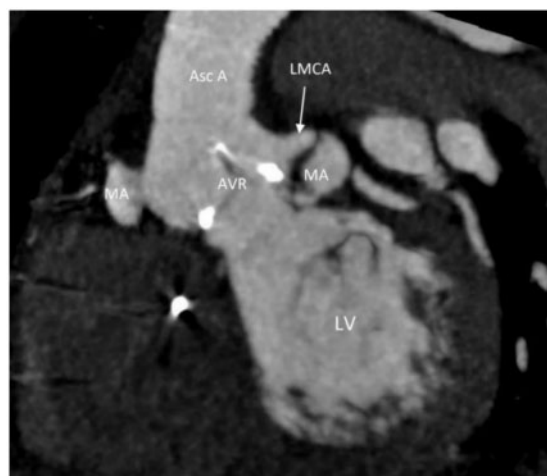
Post-operative computed tomography coronary angiogram image of mycotic aneurysms and redo aortic valve replacement. Outpouching from the right coronary cusp resulting in abnormal cavity consistent with previously 'mycotic or pseudo-aneurysm' measuring maximum length 13 mm and diameter 6 mm. Another pseudo-aneurysm can be seen arising below the aortic valve (left ventricular outflow tract) and outpouching towards the left main coronary artery measuring in length 23 mm, width 15 mm, and narrow neck 3 mm. Asc A, ascending aorta; AVR, aortic valve replacement (bioprosthetic); LMCA, left main coronary artery; LV, left ventricle; MA, mycotic aneurysms.
